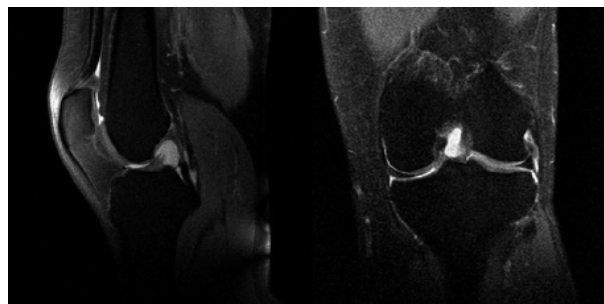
PCL associated ganglion cyst with ACL rupture in a T2 weighted MRI.
